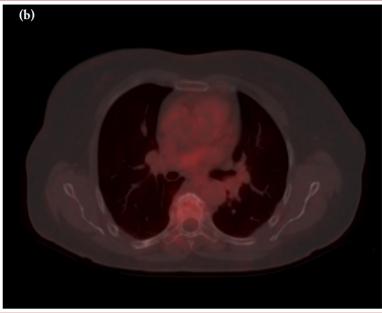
a,b. FDG PET-CT: remarkable decrease in FDG uptake in the vertebrae and discs on the 3rd month after treatment for Brucella.
